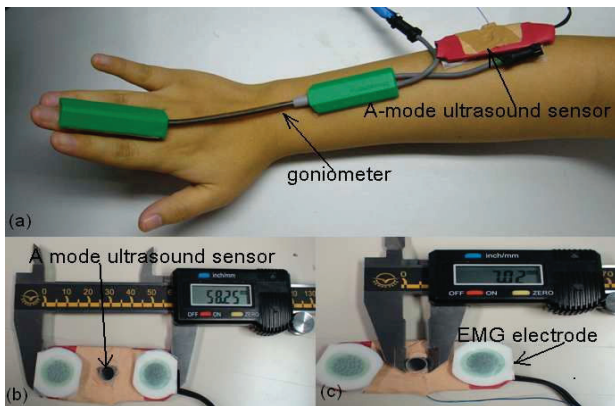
(a) Placement of the 1D ultrasound transducer, EMG electrodes and goniometer on the extensor carpi radialis muscle when subject was doing wrist extension. Ultrasound gel applied between the ultrasound transducer and skin to aid acoustic coupling. (b) The length of the three sensors was 5.8 cm. (c) The diameter of A-mode ultrasound sensor was 0.7 cm
